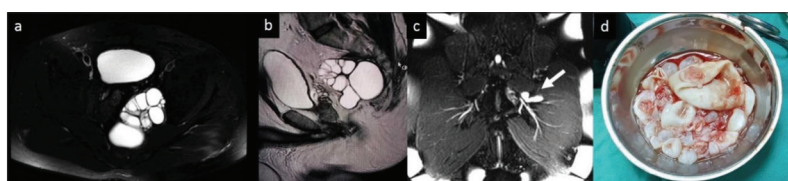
Case 15: a 35-year-old male with hydatid cyst; a and b – preoperative magnetic resonance imaging before the first surgery, which shows multiloculated septated cystic lesion at the presacral area; c – the patient presented to our clinic one year postoperatively; magnetic resonance imaging demonstrated a 43 × 14 mm lesion inferior to left piriformis muscle between gluteus medius and maximus (white arrow); d – intraoperative view of daughter cysts
